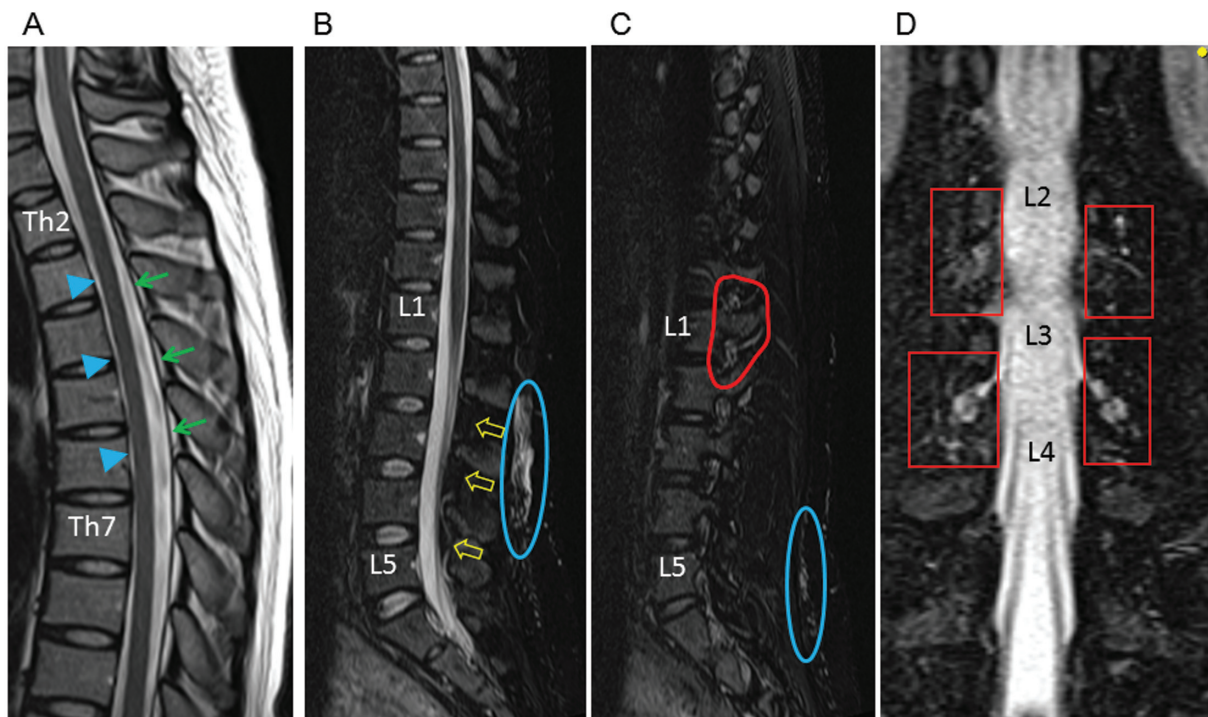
Spinal MRI 6 days after the epidural blood patch treatment in case 1. Midsagittal T2WI at the thoracic level (A) shows improvement in the anterior shift of the spinal cord (*arrowheads*) and the normally repositioned dura mater (*arrows*). Midsagittal T2-FS image at the lumbar level (B) shows an almost vanished DTS (*open arrows*) and reduced subcutaneous cerebrospinal fluid collection (*blue ellipse*). Left paramedian sagittal T2-FS image at the lumbar level (C) shows remarkably reduced exudation around the dural sleeves (*encircled by red line*). Coronal T2-FS images at the lumbar level (D) also show reduced CSF exudation around the dural sleeves (*red squares*).
